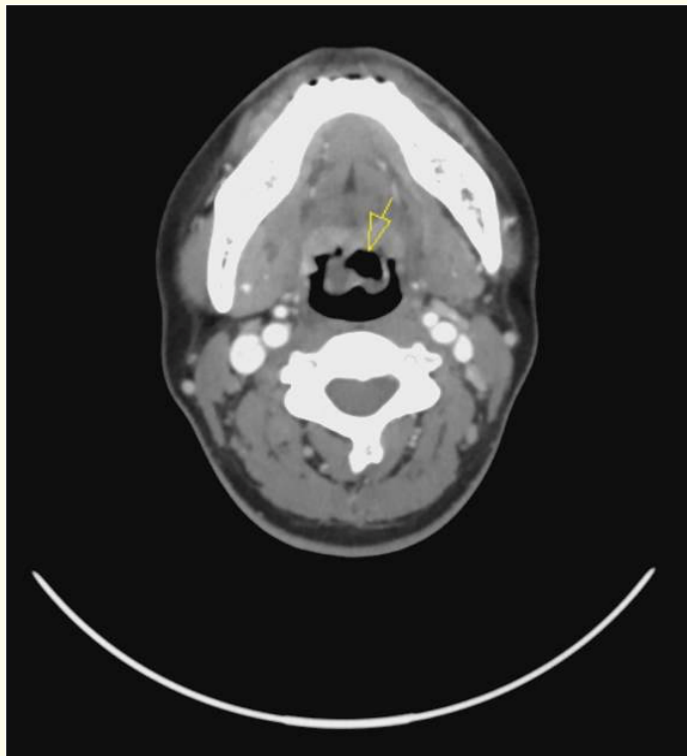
CT neck axial view shows gas filled epiglottis (yellow arrow).
